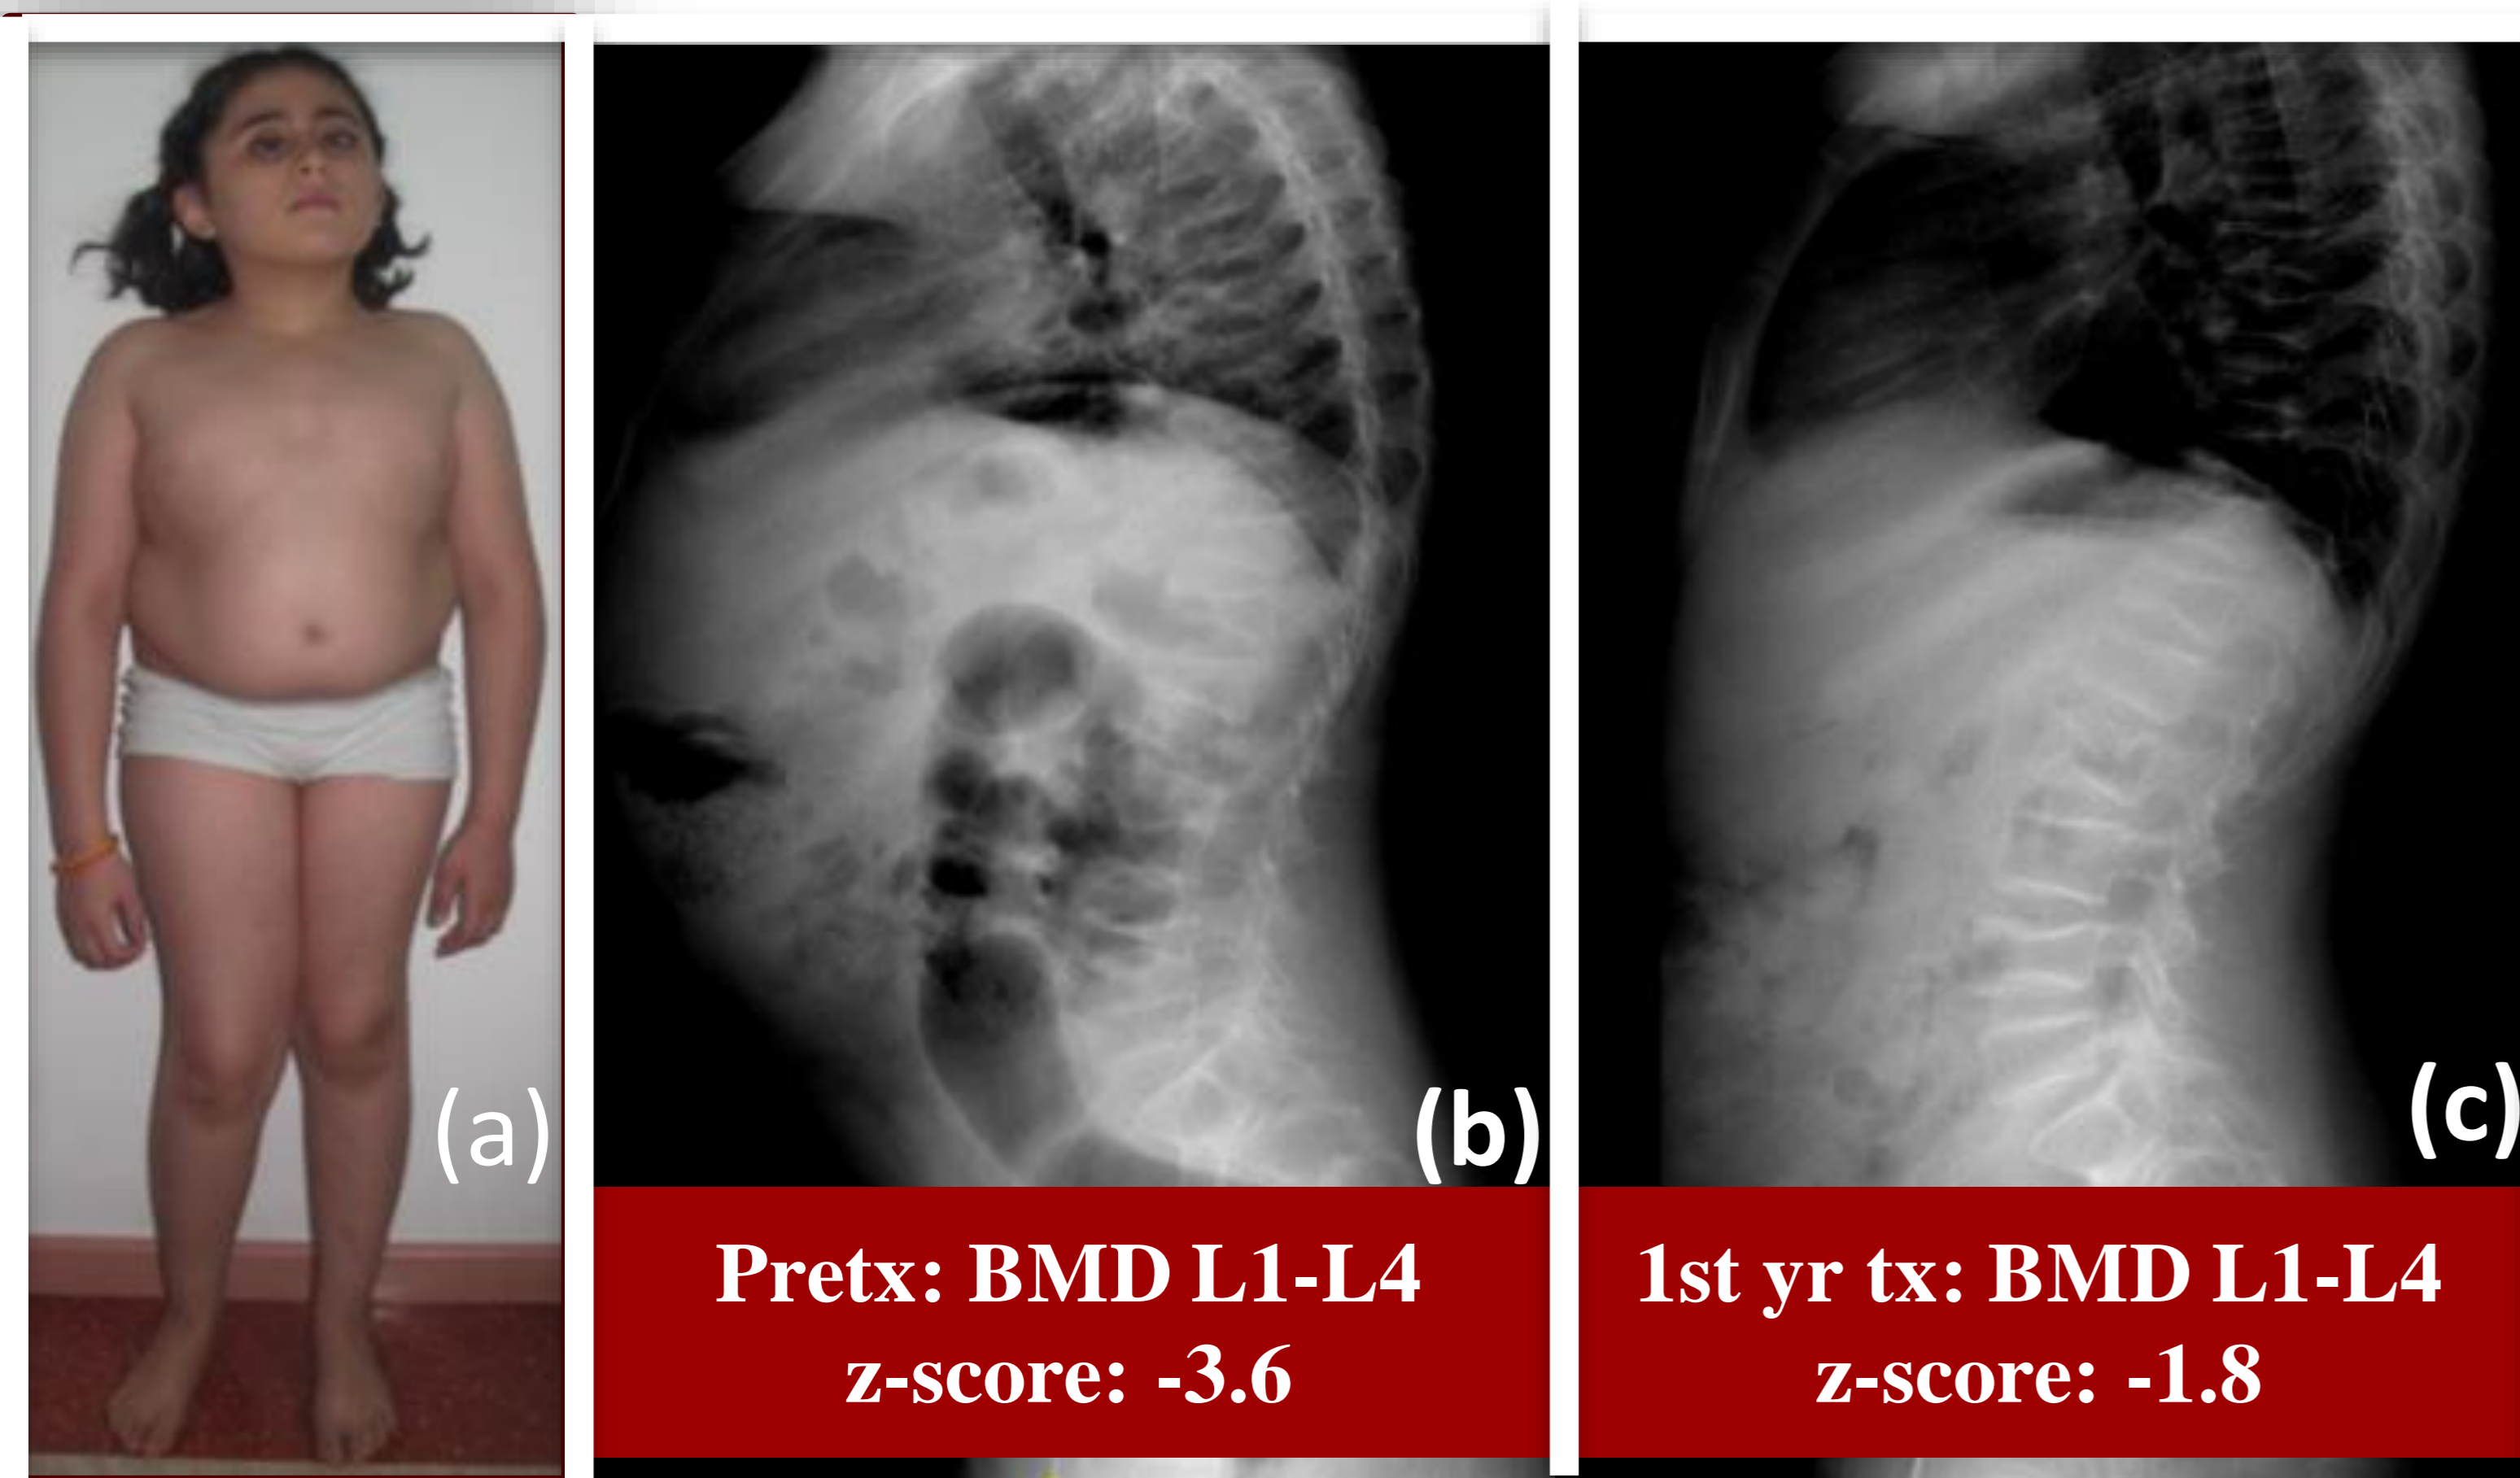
(a) Physical features of the patient at admission, X-rays of the patient at (b) admission and (c) following the first year of bisphosphonate treatment .
